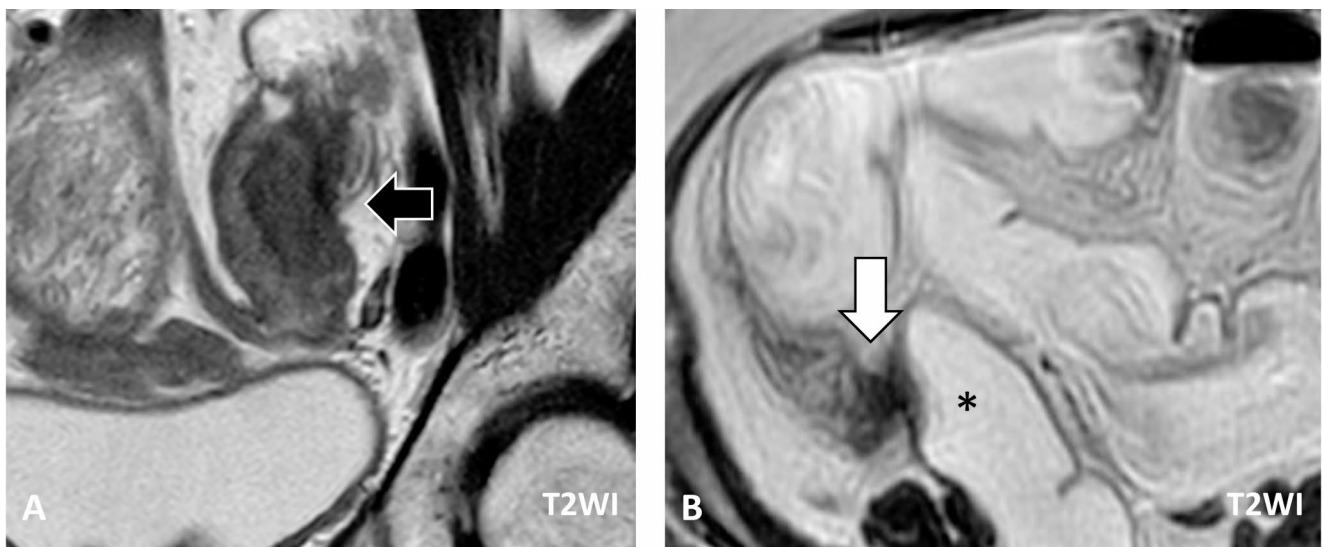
A 40-year-old woman with abdominal pain. Pelvic MRI: axial T2WI demonstrates a low T2WI mural thickening of the sigmoid colon with a characteristic “mushroom cap” appearance, consistent with bowel endometriosis B 38-year-old woman with intermittent severe
